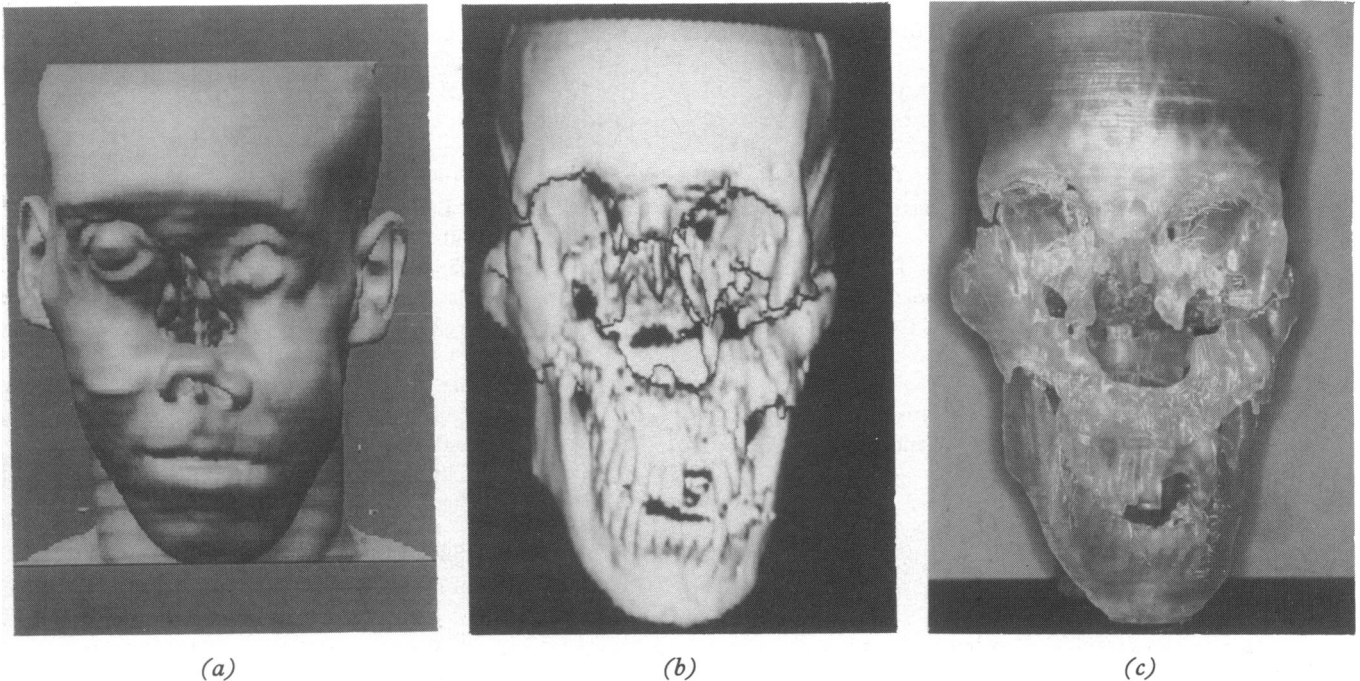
Case 2 showing (a) 3-D MRI of the facial soft tissues (b) 3-D CT scan showing the bony facial skeleton and (c) the SLA model.
